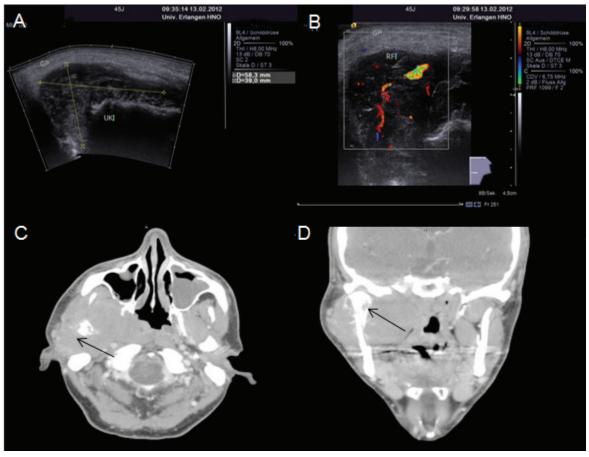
(A,B) Ultrasound image of the parotid tumour on the right side, showing a highly suspicious, hypoechoic, inhomogeneous, diffusely perfused, polycyclic intraparotid space-occupying lesion with unclear boundaries, 6×4 cm in size. (C) Axial contrast computed tomography of the head and neck shows a space-occupying lesion with soft-tissue density, 7.5×5.7 cm in size, infiltrating the right masticator space and parotid space. Medially, the tumour extends into the parapharyngeal space. (D) Coronal contrast computed tomography of the head and neck shows osteolytic destruction of the right ascending branch of the mandible with destruction of the head of the mandible (arrow). Cranially, the space-occupying lesion extends up to the base of the skull, but does not appear to be infiltrating it.
